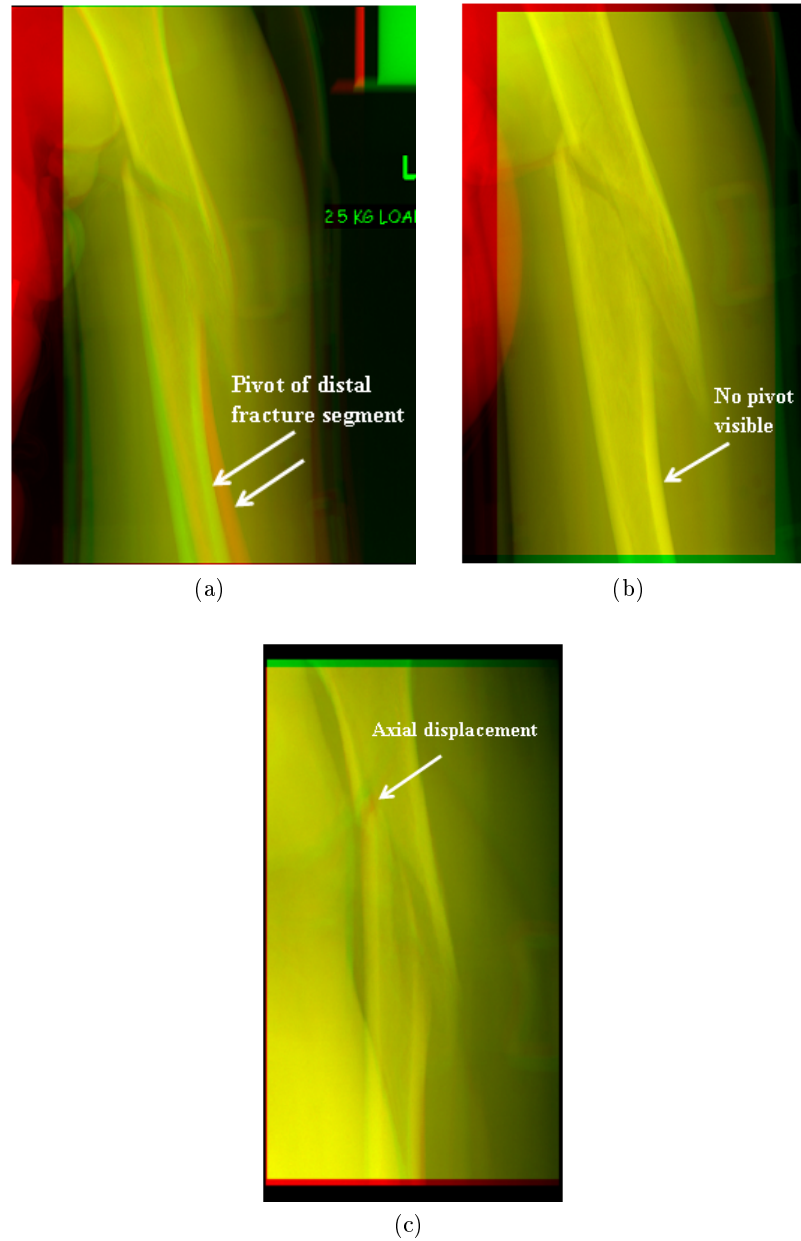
Alignment of the loaded and unloaded X-rays for a) patient 6 first follow-up, b) patient 6 second follow-up and c) patient 7 first follow-up.
